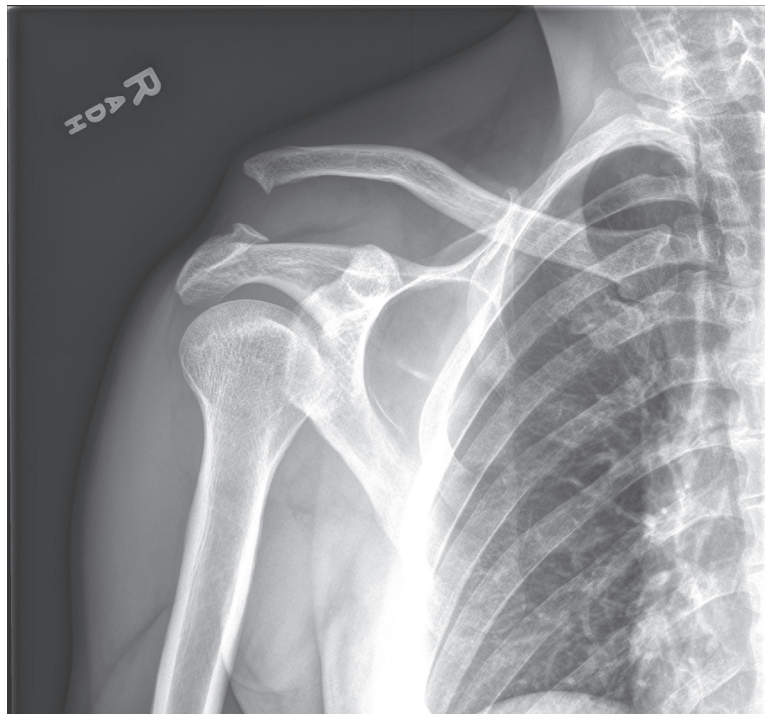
Antero-posterior shoulder X-ray demonstrates superior displacement of the lateral right clavicle in relation to the acromion, in keeping with acromioclavicular joint dislocation.
